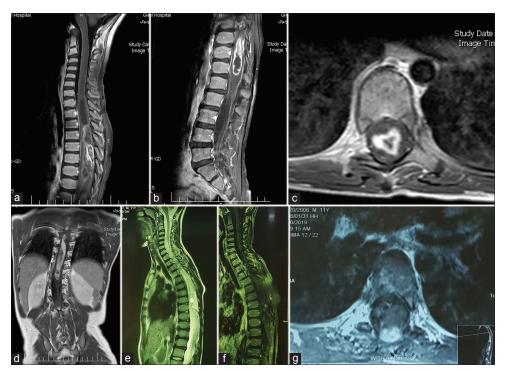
Preoperative magnetic resonance imaging (MRI) with gadolinium showed an expansile intramedullary tumor of thoracic cord and conus medullaris with irregular heterogeneous enhancement and some cystic changes on sagittal (a and b) and axial (c) views in a 9-year-old patient with severe thoracolumbar scoliosis (d). After surgical treatment, 2 years follow-up MRI reveals an evidence of minimal cord herniation toward laminectomy sites and intramedullary cystic changes (sagittal T2 sequence), (e) with minimal enhancement on sagittal (f) and axial (g) views.
